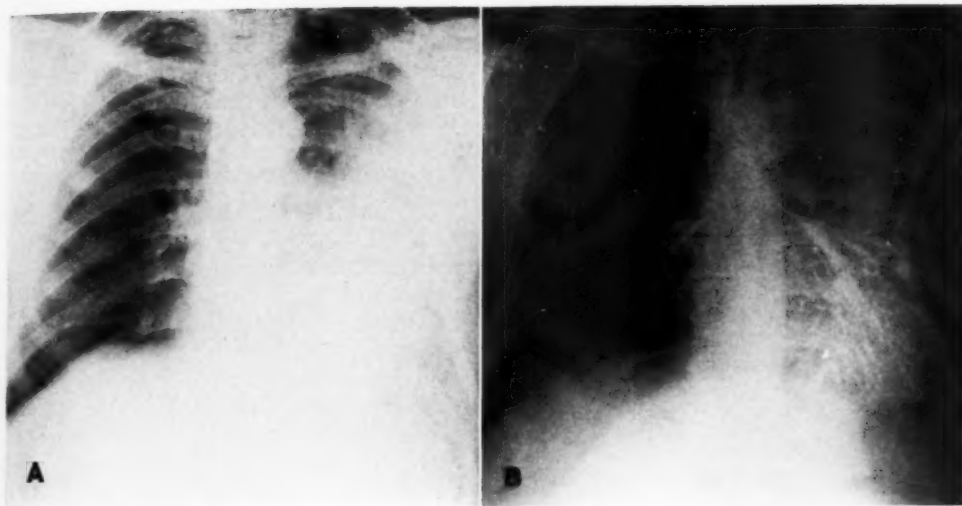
Case IV. A. Initial roentgenogram, Dec. 13, 1948. There is dense consolidation of the lower two-thirds of the left lung. B. Bronchogram showing at least one small cavity in the area of disease. Other small rarefactions could be seen in overexposed roentgenograms.
